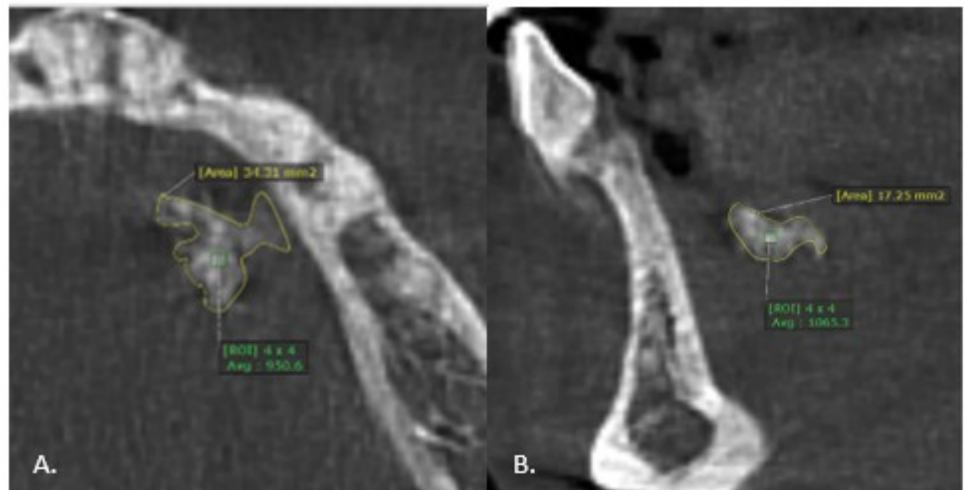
CBCT analysis, (A) A right mandible sialolith lesions (yellow border) from axial view, (B) Sagittal view shows the radiopaque lesion (yellow border) did not involve mandibular bone structure
